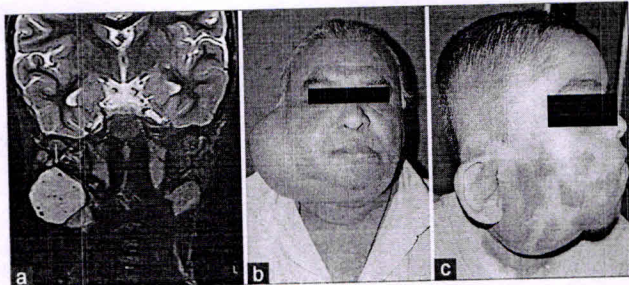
(a) T2-weighted postcontrast magnetic resonance imaging of right parotid hemangioma showing sequential centripetal enhancement of hyperintense lesion with multiple calcified foci. (b) Frontal view of high-grade carcinoma ex pleomorphic adenoma of right parotid gland. (c) Right profile view of neurofibromatosis of facial nerve
